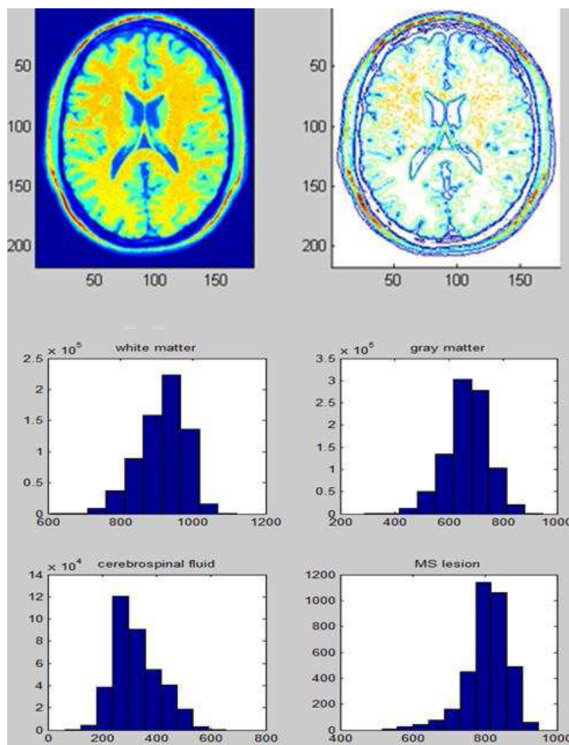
A T1-w MRI image with its contour plot and intensity histograms of WM, GM, CSF and MS lesions.
